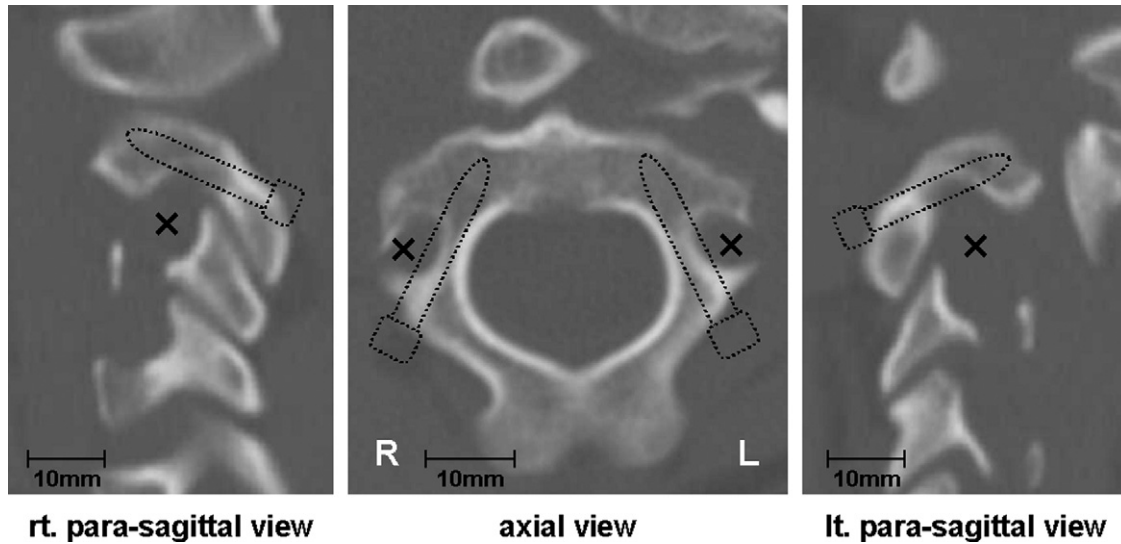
Morphologic analysis of C2 pedicles by CT imaging in case 1. Insertion of pedicle screws was judged dangerous on both sides by CT imaging. (lt, left; rt, right.)
